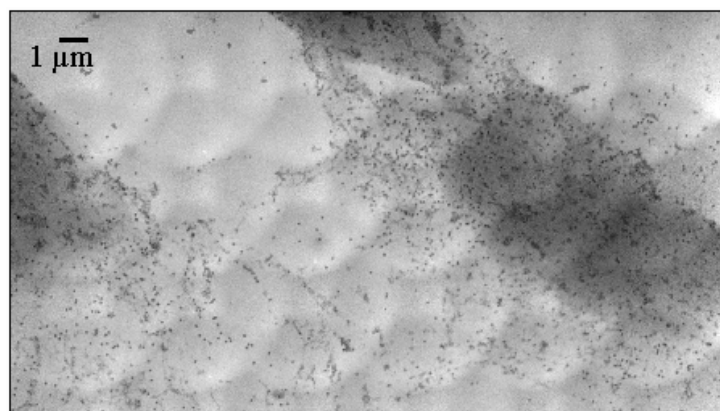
Tiled x-ray image of a Triton X-100 extracted C32 melanoma cell. Extracted cell was incubated with OKM5, followed by immunogold beads enhanced with silver.
